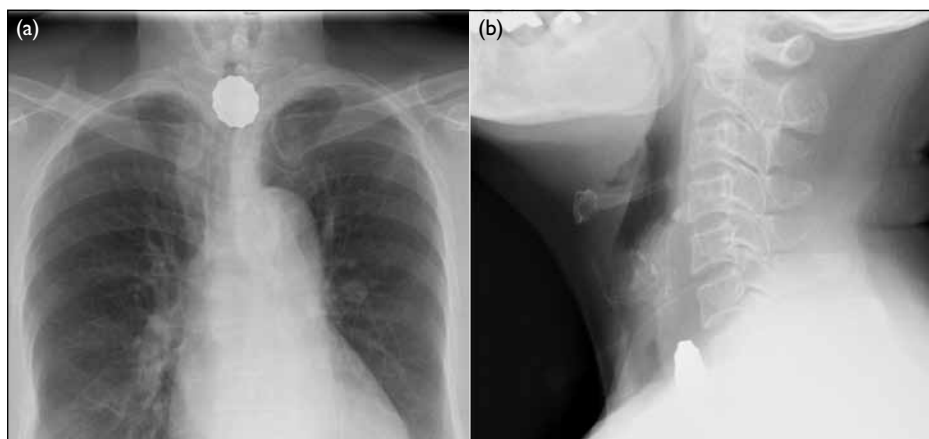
(a) Chest X-ray: anterolateral, and (b) lateral X-ray of neck
